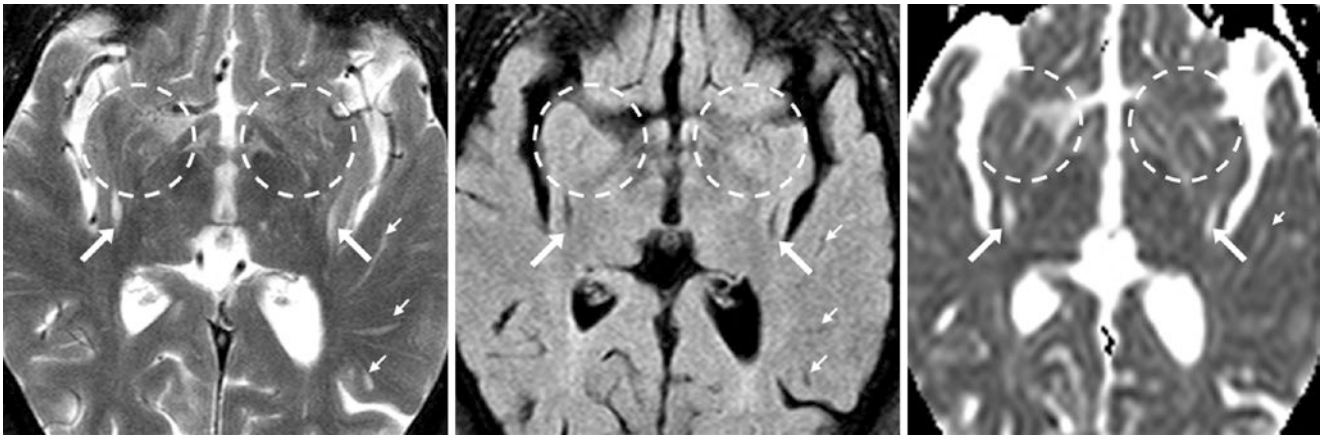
A 52 year old had bilateral dilated PVSs of the posterior putamina/insula (*arrows*), also with poorly defined PVSs more anteriorly of the anterior perforated substance on axial T2WI (*left*). All PVSs suppress on FLAIR (*middle*) and are hyperintense on ADC maps (*right*). The ill-defined PVSs border on being *état criblé* (*dashed circles*)
